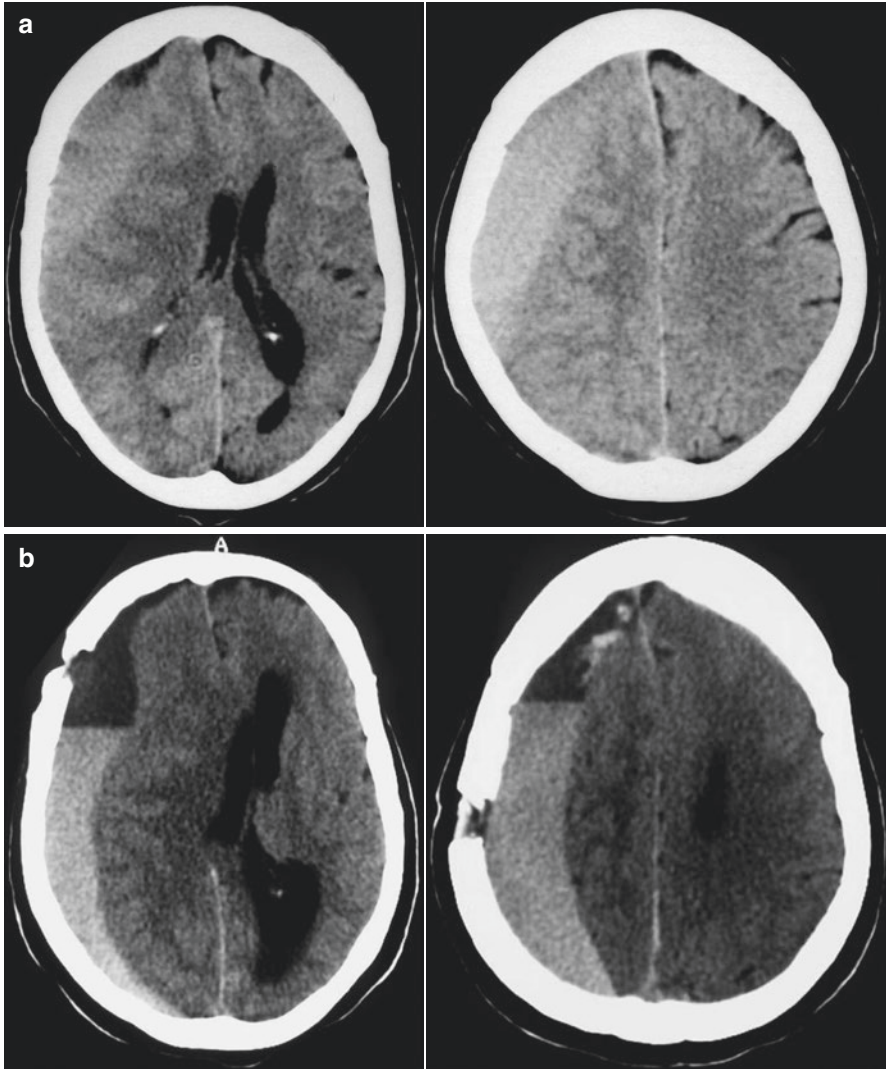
Recurrence of a right chronic subdural hematoma treated 6 weeks previously via two burr holes with subdural closed-system drainage (reappearance of neurological disorders). Initial (a) and postoperative control CT scan performed 6 weeks later (b)
